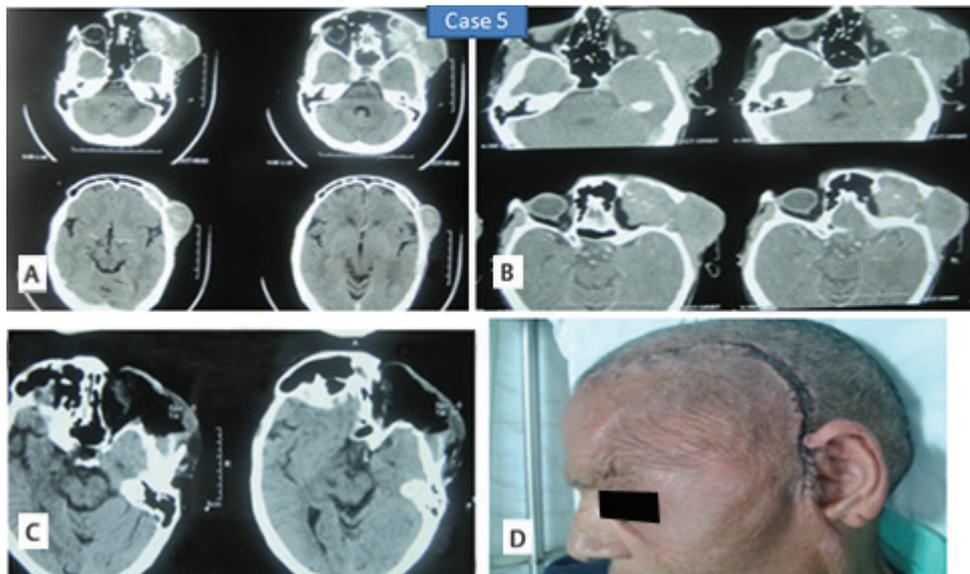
Case 5. (A) Preoperative axial section of CT scan showing pleomorphic adenoma of minor salivary gland involving ITF with orbital extension and erosion of zygomatic bone. (B) Preoperative axial section of CT scan showing pleomorphic adenoma of minor salivary gland involving ITF with orbital extension and erosion of zygomatic bone. (C) Postoperative axial section CT scan showing complete removal of tumor. (D) Patient image showing postoperative scar of question mark incision. CT, computed tomography; ITF, infratemporal fossa.
